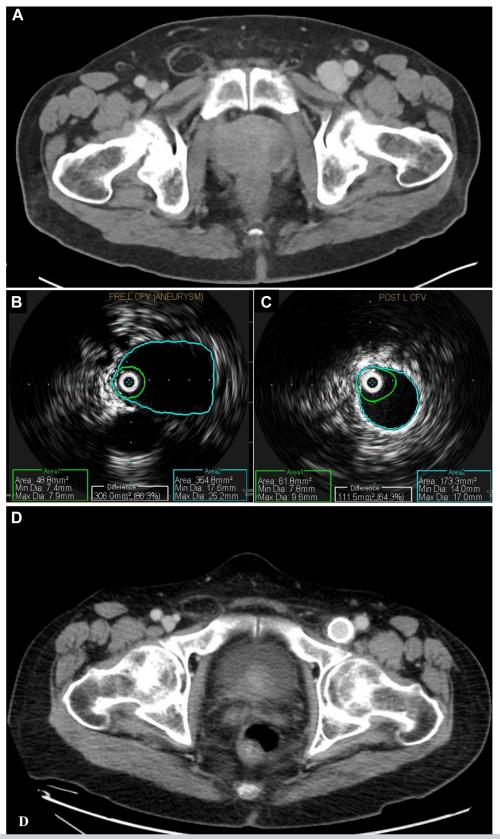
A, Axial computed tomography venography (CTV) image depicting the left common femoral vein aneurysm in patient 2 before intervention. Intraprocedural IVUS images demonstrating the left common femoral venous aneurysm before stenting (B) and after successful stent exclusion (C). D, Axial CTV image depicting the left common femoral vein aneurysm in patient 2 after successful stent exclusion and remodeling at 4 months after the procedure.
